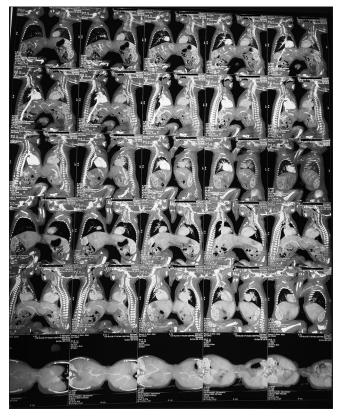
Magnetic resonance imaging of the twin babies revealing extent of organ sharing
